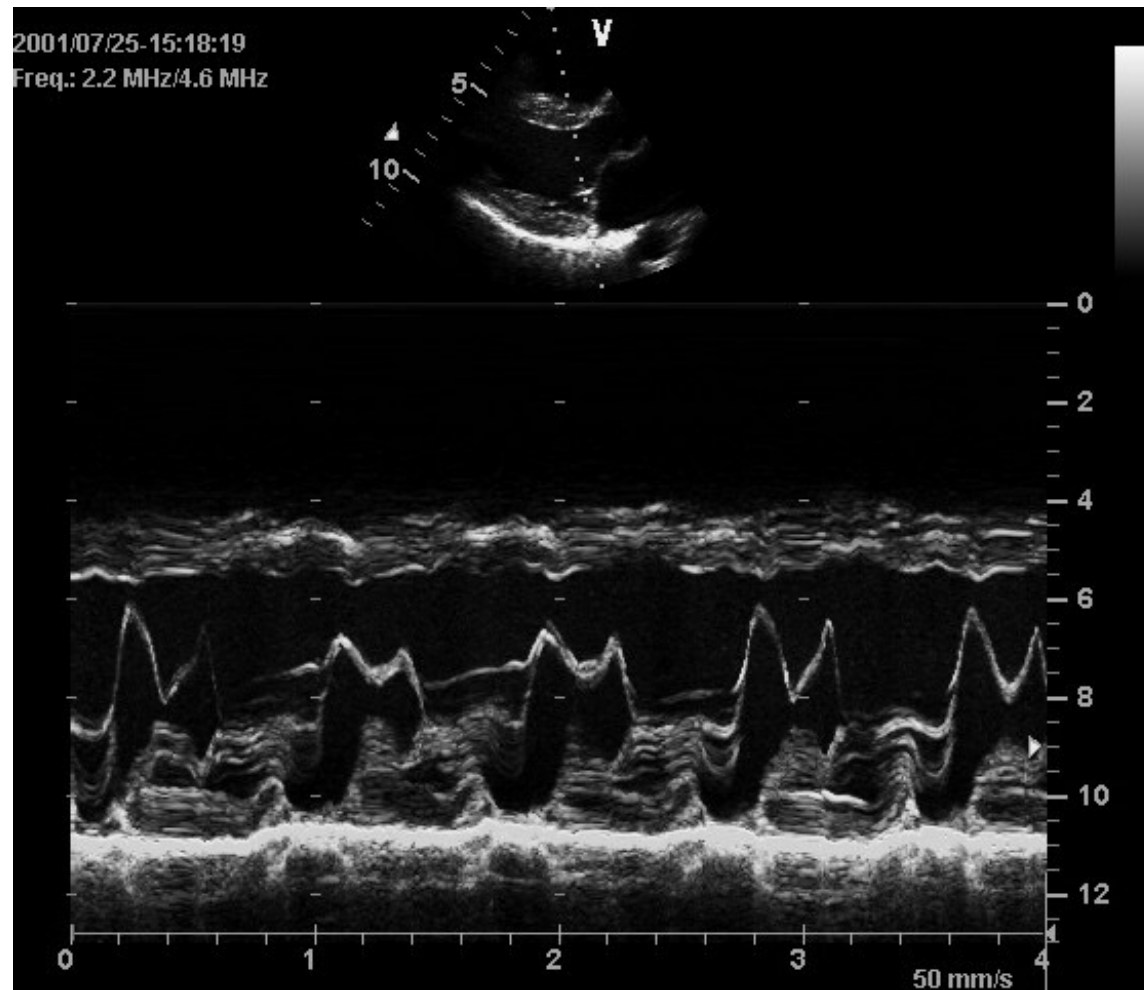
Time-motion ultrasound scan of the mitral valve of the heart. The central trace follows the motions of the mitral valve (MV) over a 3-s period, encompassing three cardiac cycles. The other traces correspond to other relatively static structures, such as the interventricular septum (IVS) and the walls of the left atrium (LA).
